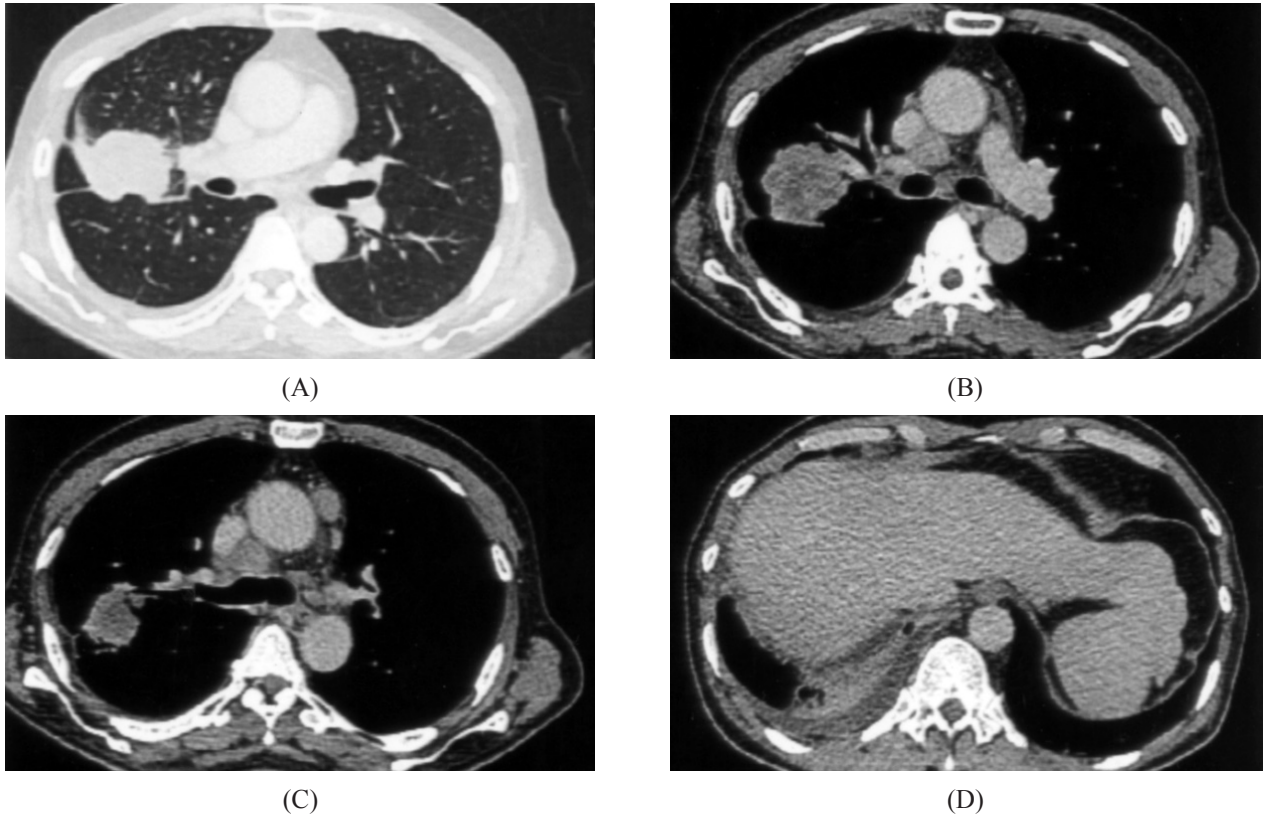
Computed tomography scan of the chest showing a right-upper-lobe tumor, numerous pleural nodulations, mild right-sided pleural effusion, and enlarged lymph nodes at the right hilar, pretracheal retrocaval, subcarina, and contralateral prevascular regions.
